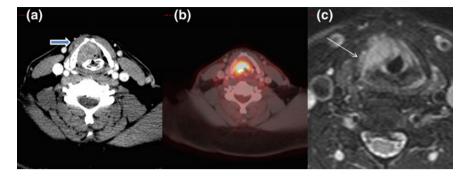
Laryngeal cancer. a Contrast CT. b PET-CT. c Axial T2 weighted. Right laryngeal tumor with extension to the anterior commissure and to the contralateral side. Increased uptake on PET-CT. MRI shows subtle edema in the cartilage (thin *arrow*) and CT shows minimal asymmetric fullness in right strap muscles (*thick arrow*) further contributing to the upstaging of the tumor
